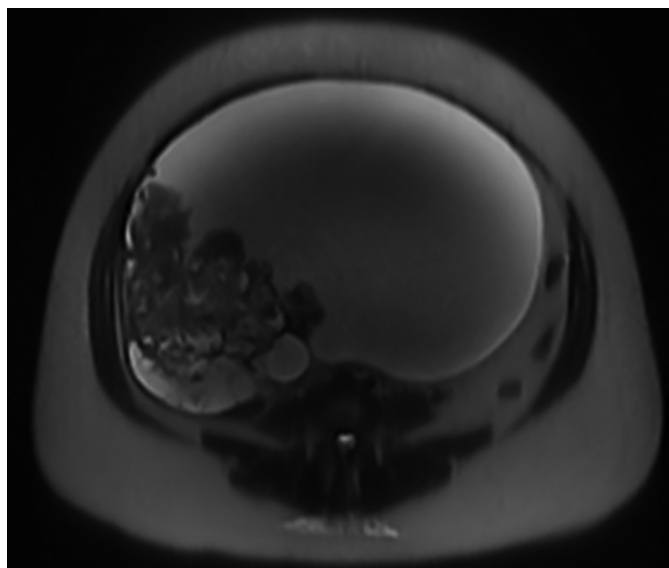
MRI showing the pelvic mass at the time of diagnosis.
